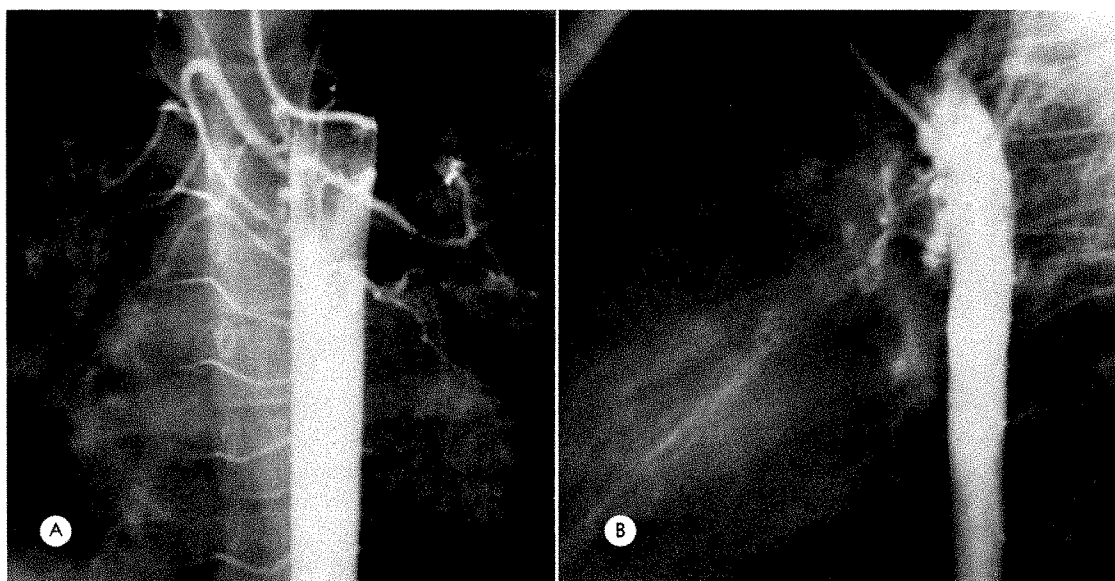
Bronchial arteries in fibrocystic emphysema in a child. (A) Anteroposterior arteriogram shows the enlarged, tortuous bronchial arteries. Normally, they are the size of the intercostals. (B) Lateral roentgenogram shows rich pleural plexuses extending along the long fissures.
